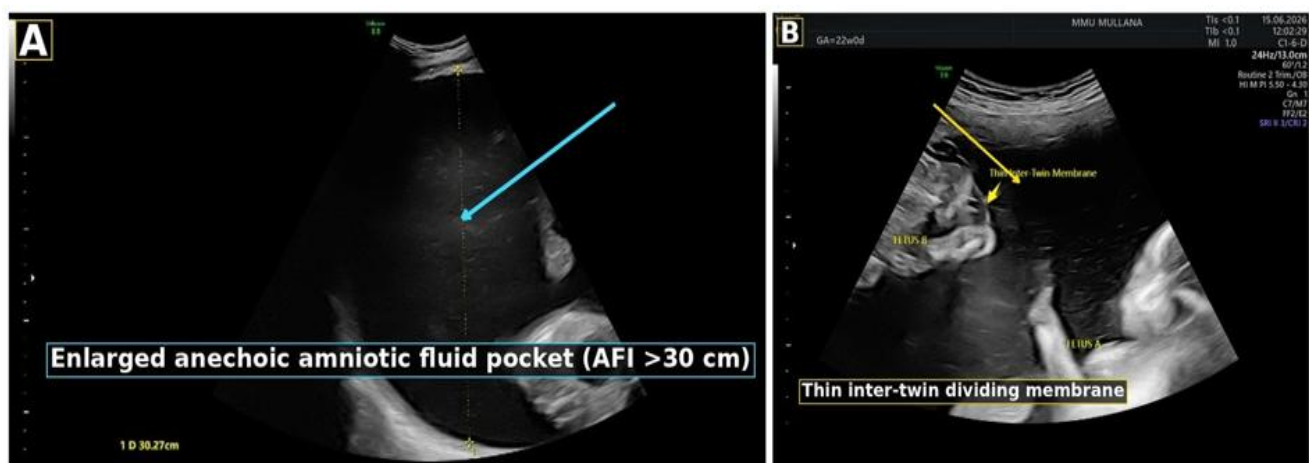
Obstetric ultrasonography at 26 weeks of gestation demonstrating the polyhydramnios-oligohydramnios sequence, (A) Marked polyhydramnios in Twin A (recipient), with an amniotic fluid pocket measuring >30 cm on caliper assessment, (B) Thin inter-twin dividing membrane (arrow) closely applied to Twin B (donor), producing the characteristic “stuck-twin” appearance of severe oligohydramnios
